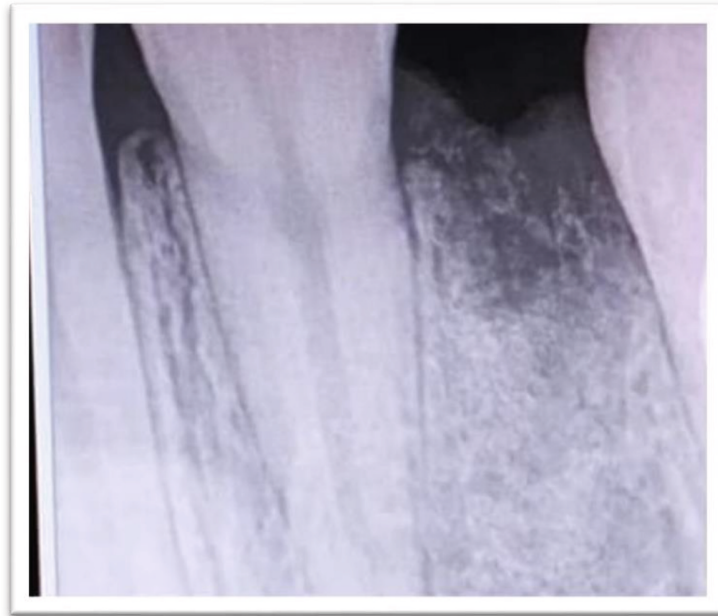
Follow-up radiograph (within 1 week) showing appreciable complete healing of cyst
